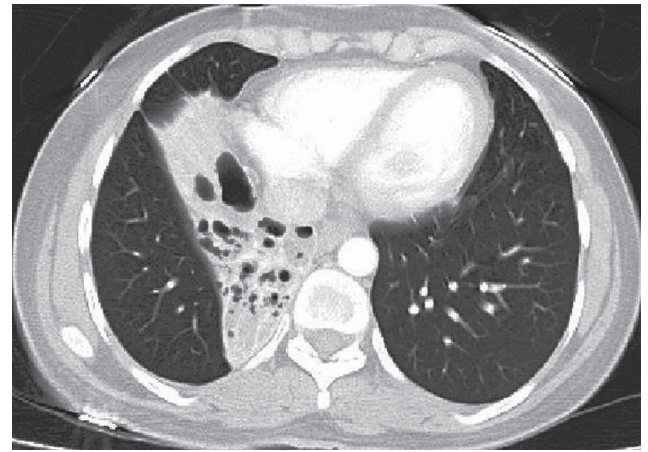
Transverse reconstructive image of thoracic CT scan shows aberrant lung tissue.
